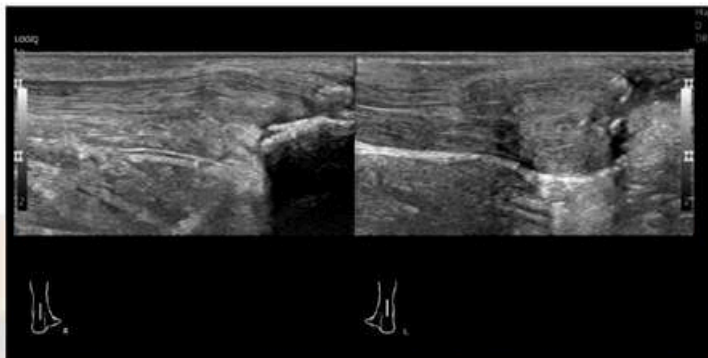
Ultrasonography image of patient Achilles tendon
